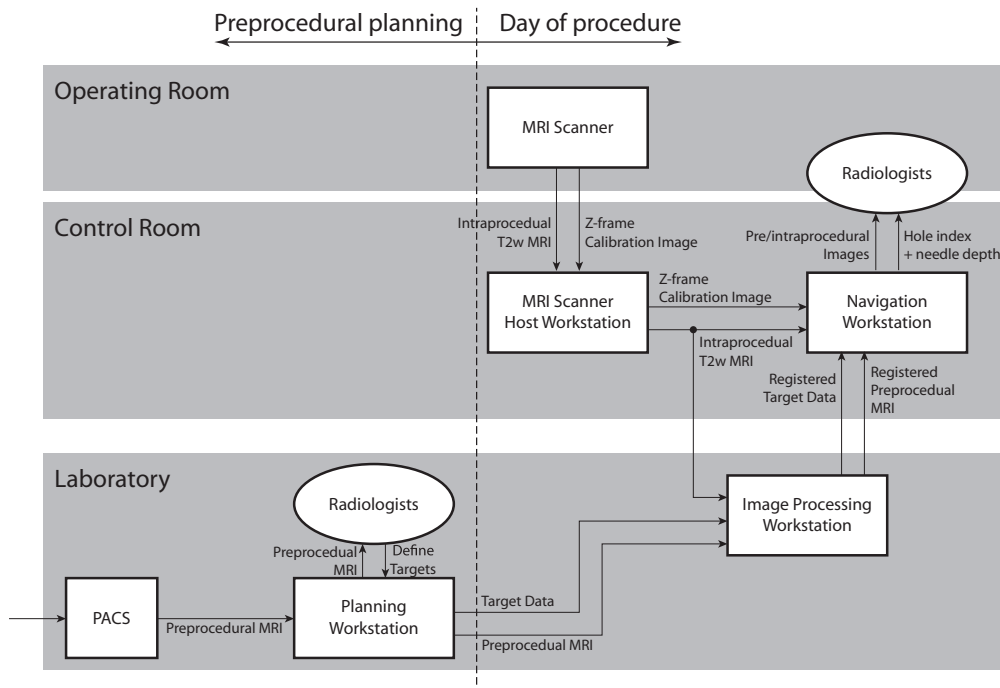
The system configuration and the data flow before and during the procedure is shown. For preprocedural planning, which took place a few days before the procedure, preprocedural MRI data, including T2W, DCE, and diffusion-weighted images were retrieved from the hospitals picture archiving and communication system (PACS). The radiologists identified the suspicious foci as biopsy targets based on the preprocedural MRI. During the procedure, intraprocedural T2W MRI acquired by the MRI scanner in the operating room was transferred from the host workstation to the navigation workstation for intraprocedural planning and the image-processing workstation for registering the preprocedural MRI and the biopsy targets to the intraprocedural MRI. The registered preprocedural MRI and registered targets were returned to the navigation workstation for the radiologists review and calculation of the template hole index and depth for guiding the needle.
